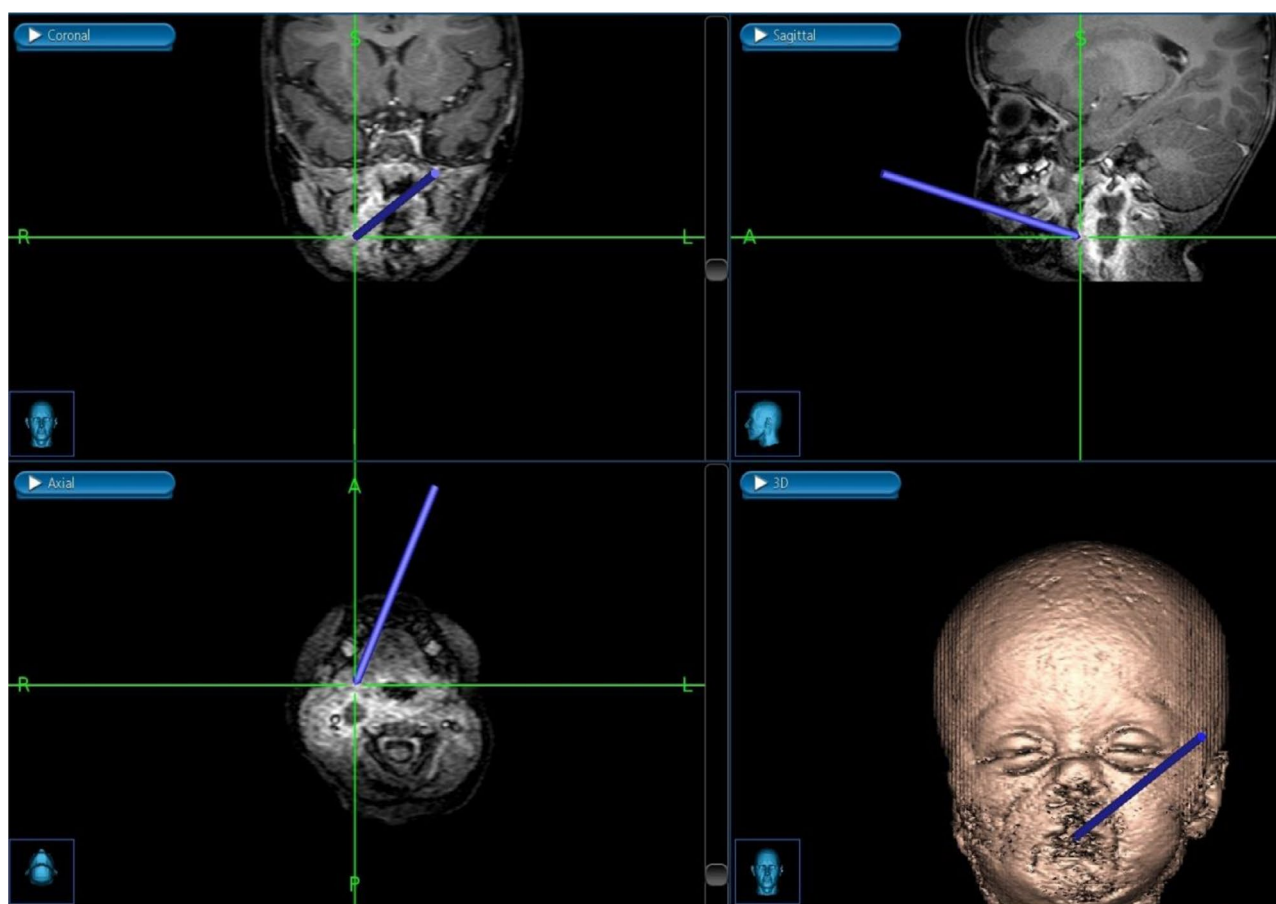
Intraoperative MRI guided navigation: The image-guided navigation probe is shown in the retropharyngeal space under live image localization using MR images in coronal, axial, and sagittal views
